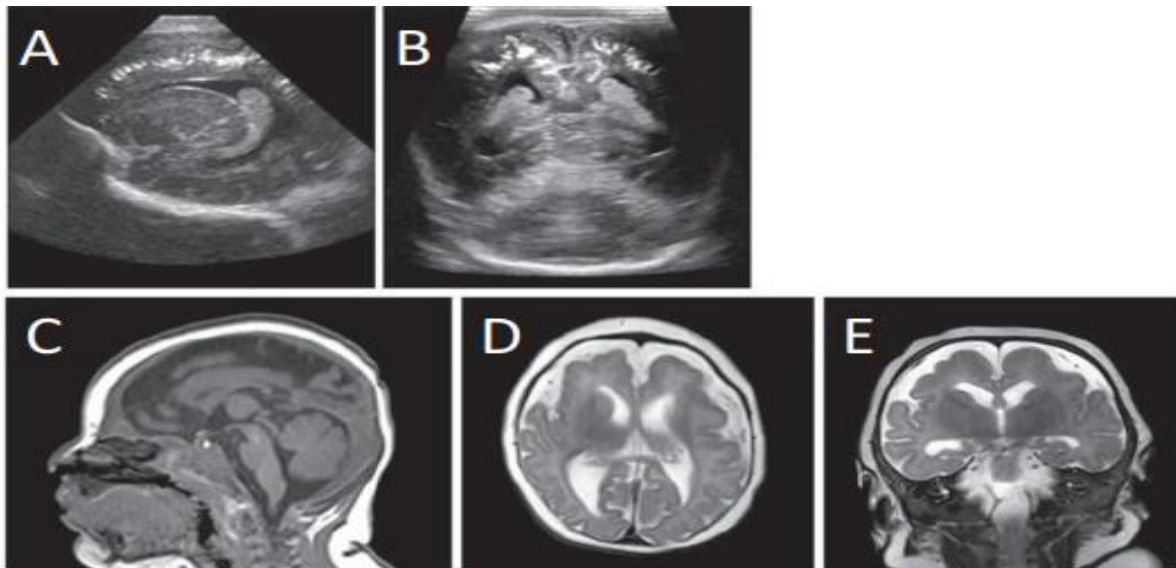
Cranial ultrasonography at one week (A, B). The periventricular and subcortical white matter show significant punctate calcifications in A's parasagittal and B's coronal images via the anterior fontanelle. (C–E) C: Sagittal MPR picture showing tiny supratentorial structures in relation to the brainstem and cerebellum, as well as a small skull in relation to the face. Axial (D) and coronal (E) T2-weighted scans displaying significant bilateral polymicrogyria, primarily in the anterior and superior frontal lobes, and tiny cerebral hemispheres with decreased white matter volume and ex vacuo dilatation of lateral ventricles.
